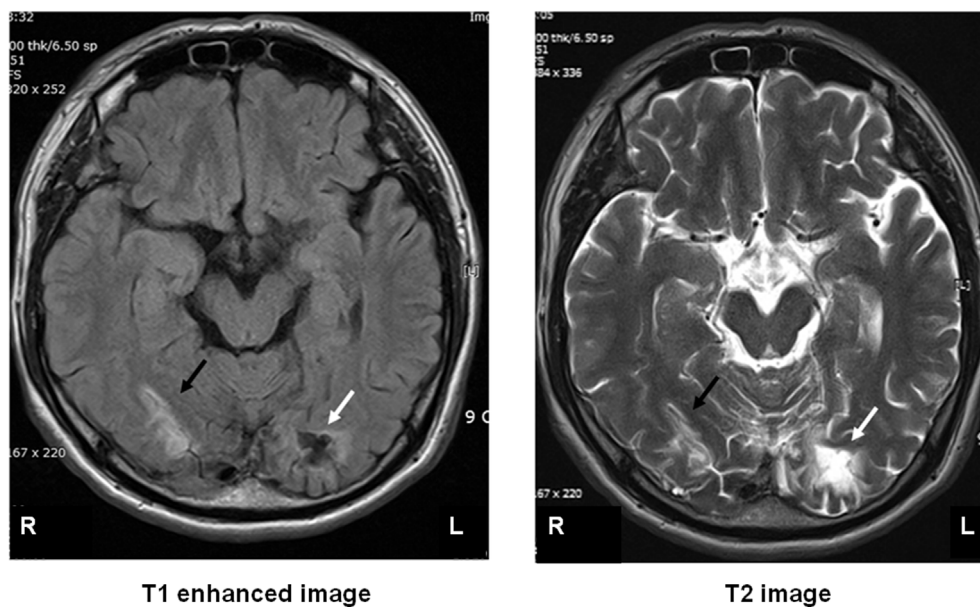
Brain magnetic resonance imaging (MRI) revealed an old infarct in the left occipital lobe (white arrow) and subacute infarcts with cortical laminar necrosis in the right occipital lobe (black arrow) (Left: T1 enhanced image, Right: T2 image, R: right, L: left).
